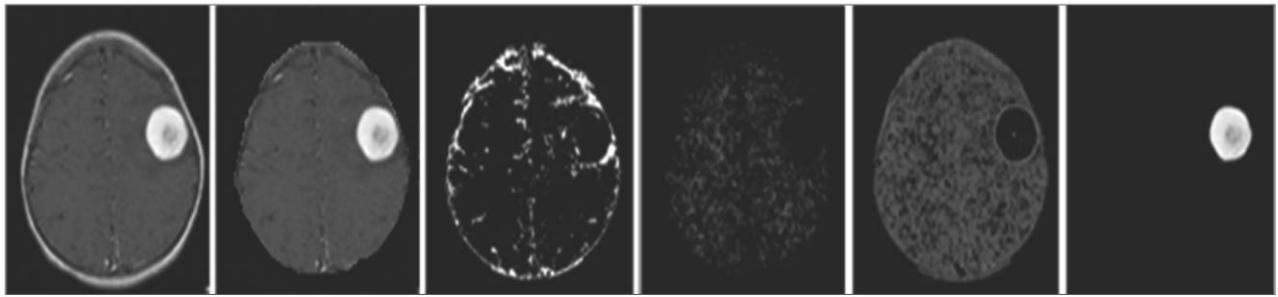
Segmented results of Brain MRI with tumor. (a) Input Brain MRI image, (b) Skull stripped image, (c) Cerebrospinal fluid image, (d) White matter, (e) Gray matter, (f) Tumor region
